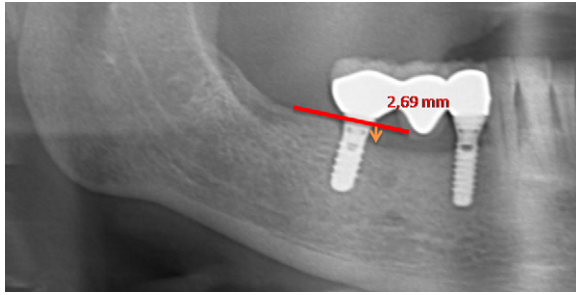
There was only mesial vertical bone loss on the control radiograph. A transverse line was observed at the junction of the prosthetic restoration and the implant neck and mesial marginal bone loss (2.69 mm) was measured.
